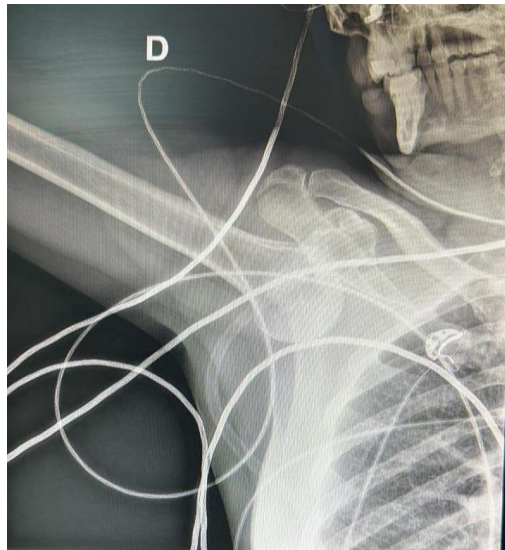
Radiograph of a right luxation Erecta
